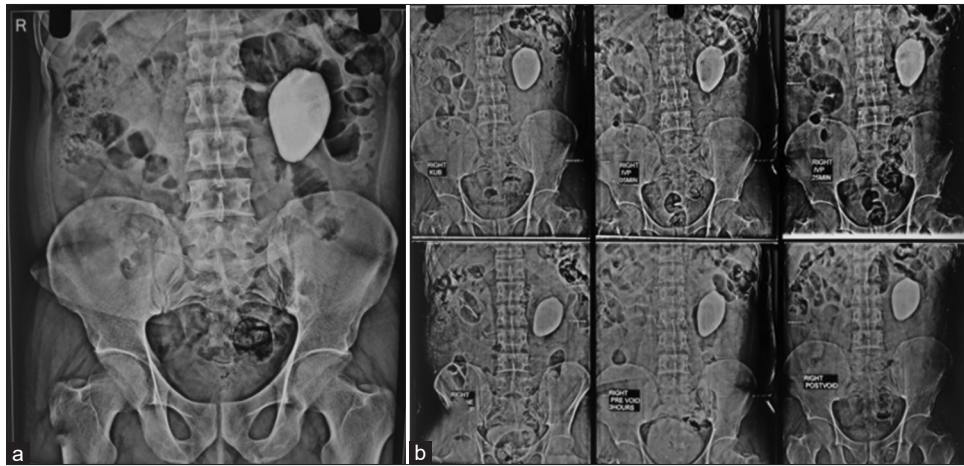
(a) X-ray kidney, ureters, and bladder, (b) Intravenous pyelography
